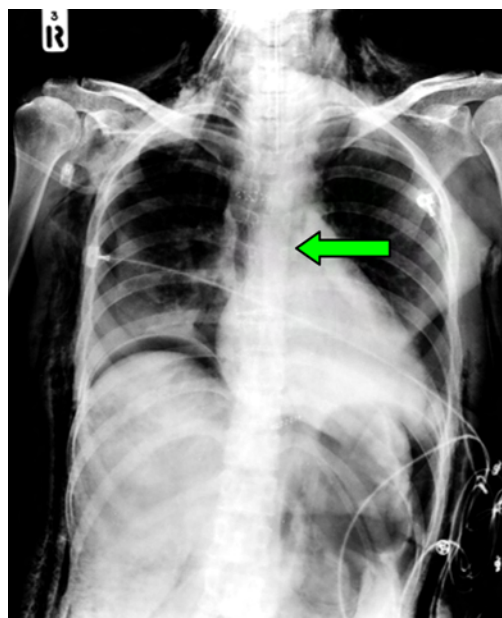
Chest X-rays showed esophageal stent in place (green arrow), pneumomediastinum and subcutaneous emphysema.
